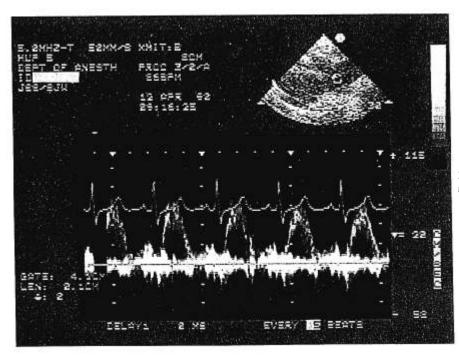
Spectral display of the pulsed-wave Doppler signal with the sample volume in the main pulmonary artery.
